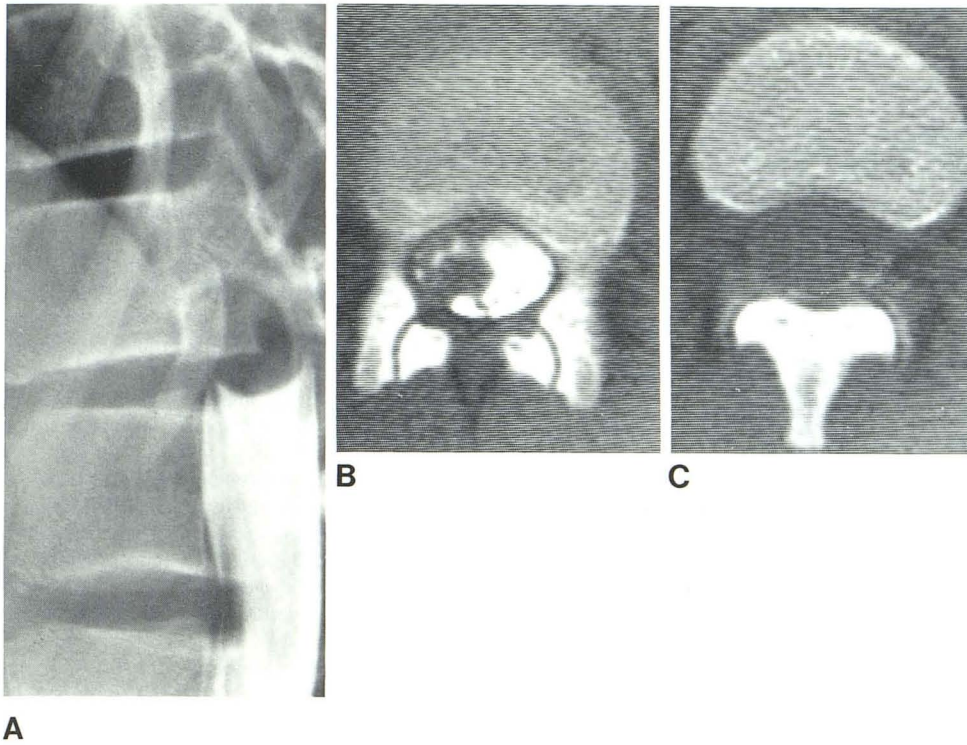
Intramedullary astrocytoma of conus medullaris in 13-year-old boy. A, Lumbar metrizamide myelogram, lateral view. Complete block with meniscuslike configuration of contrast column suggesting that mass may be intradural extramedullary in location. Note displacement of roots of cauda equina by mass. B, CT myelography at level of upper margin of L1. Inferior aspect of mass is eccentric in location and irregular and exophytic in configuration. Nerve roots lie ipsilateral and close to mass, which suggests that mass actually represents enlarged conus medullaris—extramedullary tumor would displace adjacent nerve roots to contralateral side of thecal sac. C, CT myelography at level of lower margin of T12. Enlarged conus medullaris virtually fills thecal sac.
